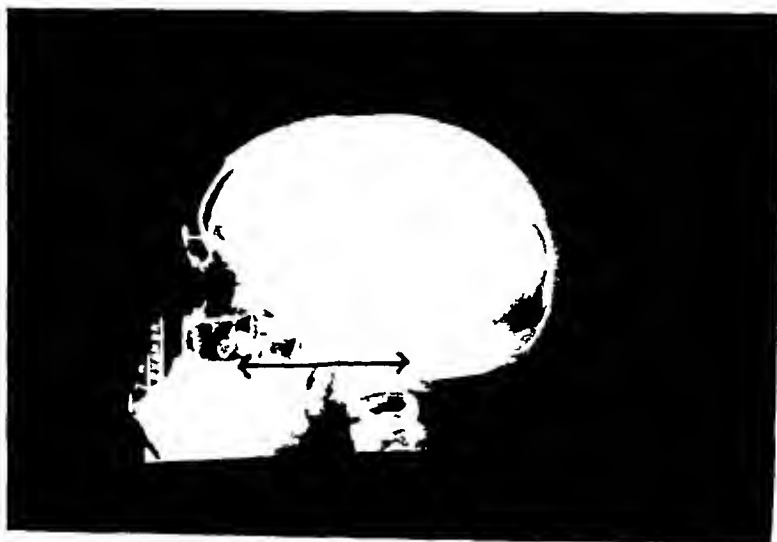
Roentgenogram of the skull shows projection of the odontoid process above the line drawn from the posterior margin of the hard palate to the posterior lip of the foramen magnum
